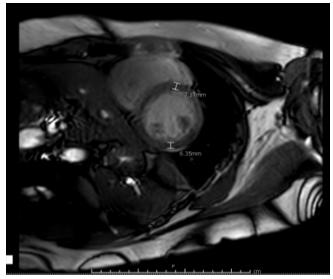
Cardiac MRI showing constrictive pericarditis with pericardial effusion.
